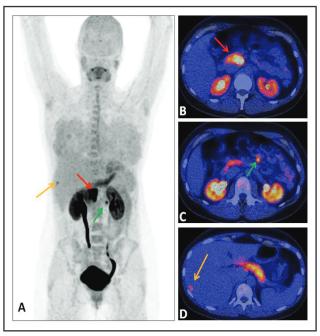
Baseline 11 C-5-hydroxy-l-tryptophan positron emission tomography (PET)-computed tomography (CT) scanning. (*A*) Coronal image and (*B*, *C*, *D*) transaxial fused PET-CT images. Red arrow: primary lesion in head of the pancreas. Green arrow: mesenterial lymph node metastasis. Yellow arrow: liver metastasis.
